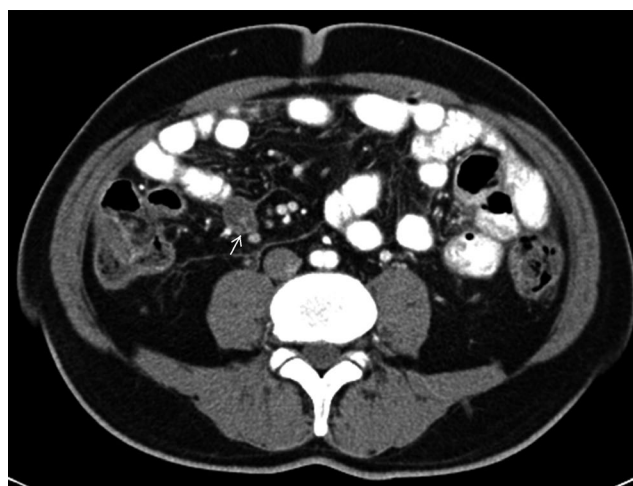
Abdominopelvic computed tomography scan shows mesenteric stranding and a thickened, nodular, and enhanced peritoneal wall
